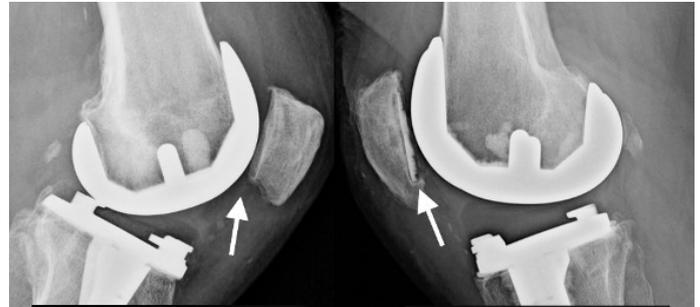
x-ray of TKP without kneecap replacement (left) and with kneecap replacement (right)
